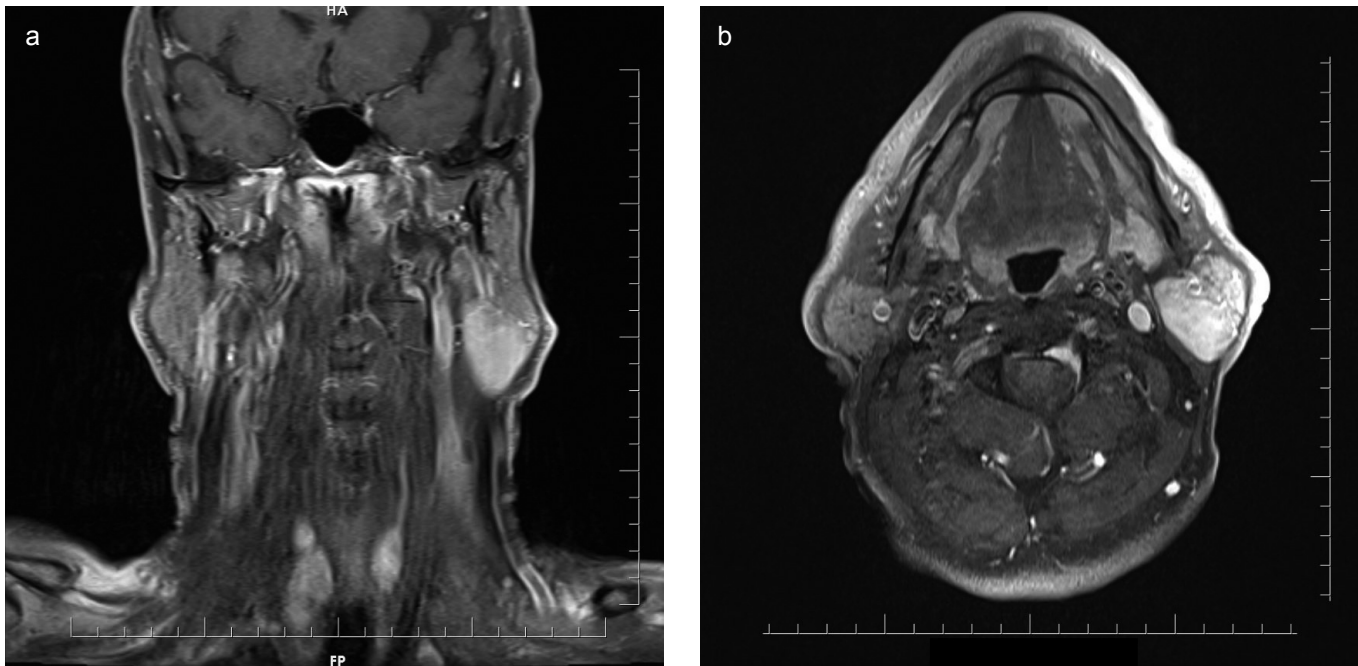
a, b. MRI of the head and neck, axial (a) and coronal (b) views of left parotid gland. The lesion measuring 32x20 mm with no marked uptake of contrast material in the inferior and posterior neighborhood of the left parotid gland, including a cystic component, which was thought to be a lymphadenopathy.
